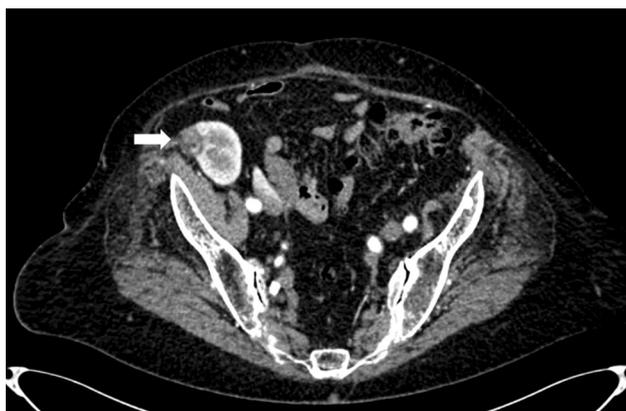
Case 1: pre-operative ce-CT scan demonstrating an exophytic ($\geq 50\%$), 2-cm-sized, vascularized, solid mass (white arrow) in the anterior-lateral aspect of the lower pole of the renal allograft, over 4 mm from the collecting system (papillary type II RCC, American Joint Committee on Cancer T1a, Fuhrman grade 2, RENAL Nephrometry Score 5a)
